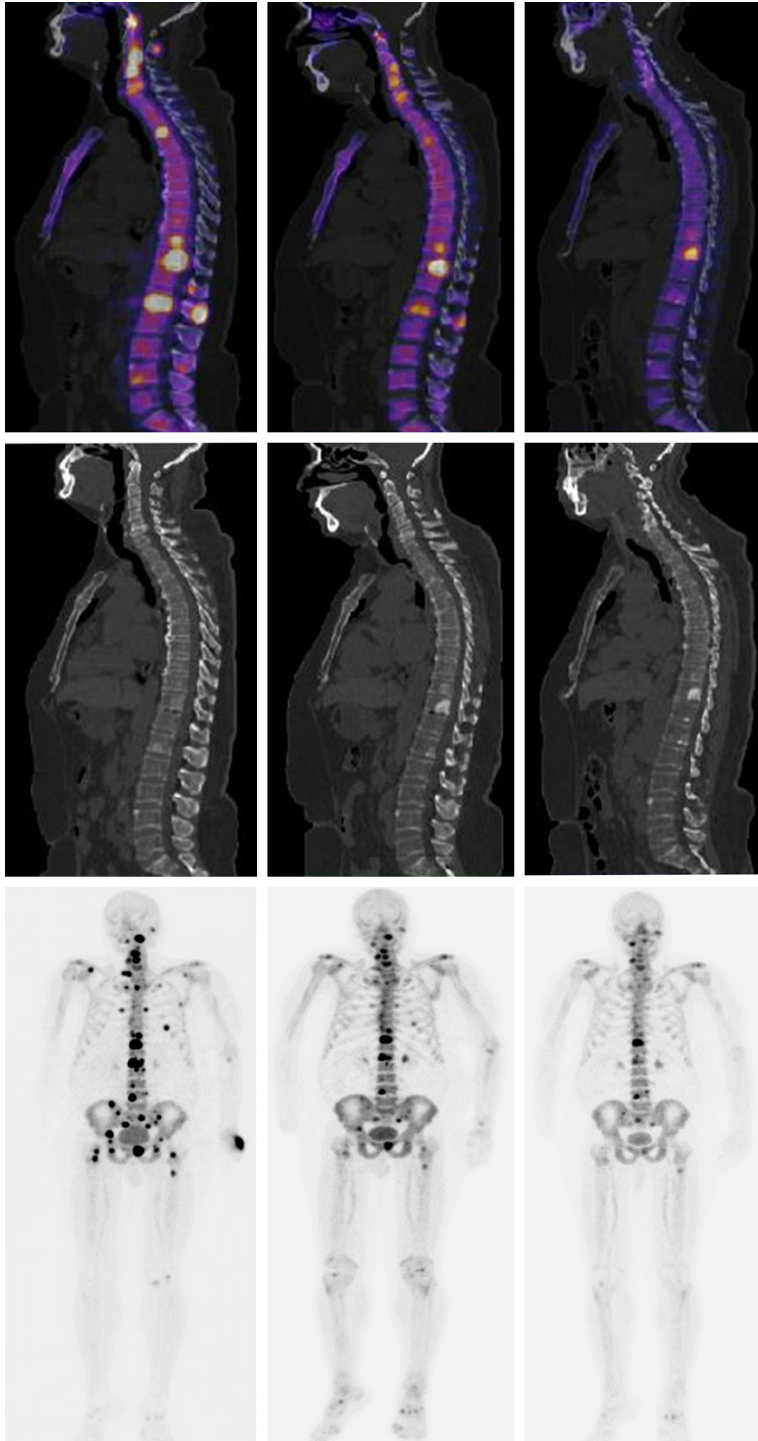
Top Left.* Fused sagittal slice of baseline ^{18}F -NaF-PET/CT and high radionuclide uptake in multiple vertebral bodies. *Top middle.* Fused sagittal slice ^{18}F -NaF-PET/CT after 3 cycles of ^{223}Ra . *Top Right.* Fused sagittal slice ^{18}F -NaF-PET/CT after 6 cycles of ^{223}Ra plus ADT, note the important osteoblastic activity. *Middle.* Sagittal slices corresponding only a CT baseline, CT after 3 cycles of ^{223}Ra and CT after 6 cycles of ^{223}Ra plus ADT, note the increased sclerotic changes. *Lower Left.* multiple sites of focal high radionuclide uptake that result in metastatic bone disease predominantly blastic type axial skeleton in the MIP ^{18}F -NaF-PET. *Lower middle.* MIP ^{18}F -NaF PET after 3 cycles of ^{223}Ra . *Lower Right.* MIP ^{18}F -NaF-PET after 6 cycles of ^{223}Ra plus ADT, note the important decreased of osteoblastic activity (patient 4).
